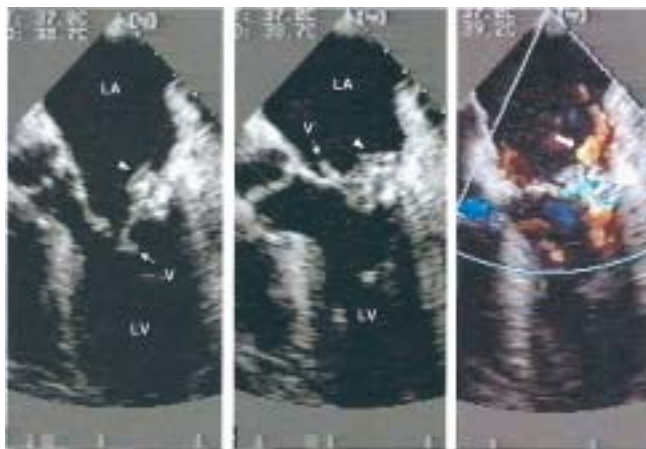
Transesophageal echocardiography. Left and middle panels (horizontal plane, diastole and systole): 'Puffed-up' aspect of the mitral annulus (arrowhead) associated with a vegetation (V). Right panel (10° oblique plane, systole): Perforation near the base of the posterior mitral leaflet (large arrow). LA: Left atrium; LV: Left ventricle.
